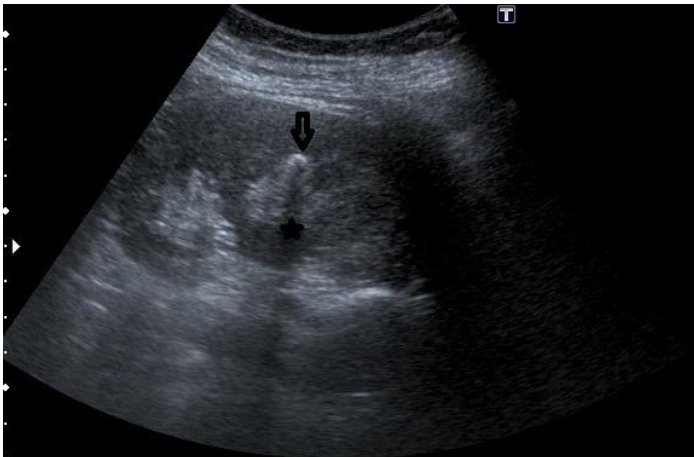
Ultrasonography image shows an echogenic foci (arrow) in calyceal system with posterior acoustic shadowing (asterisk) without any findings of obstruction.
